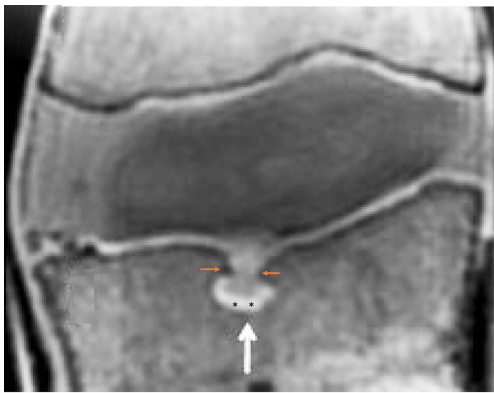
Vertebral L3 osteoporotic-like fracture and upper endplate SN type-2, as well as L2 lower endplate SN type-1A, with sagittal reconstructed *in vivo* CT image (A) and sagittal T2-weighted and T1-weighted images (B,C) as well as sagittal IR-FS-UTE images (D). T2 weighted image shows areas of bone marrow edema, especially in L3 (white asterisk). The cartilaginous endplate plate is seen on the IR-FS-UTE imaging (D), and it is discontinuous in the areas of fracture SNa entry (arrowheads and arrows in D). However, a residual amount of cartilaginous endplate can be appreciated (white arrow with a black asterisk). Reused with permission from Lombardi *et al.* (9). SN, Schmorl's node; CT, computed tomography; IR, inversion-recovery-prepared; FS, fat-saturated; UTE, ultrashort time-to-echo; SNa, Schmorl's node of acquired cause.
